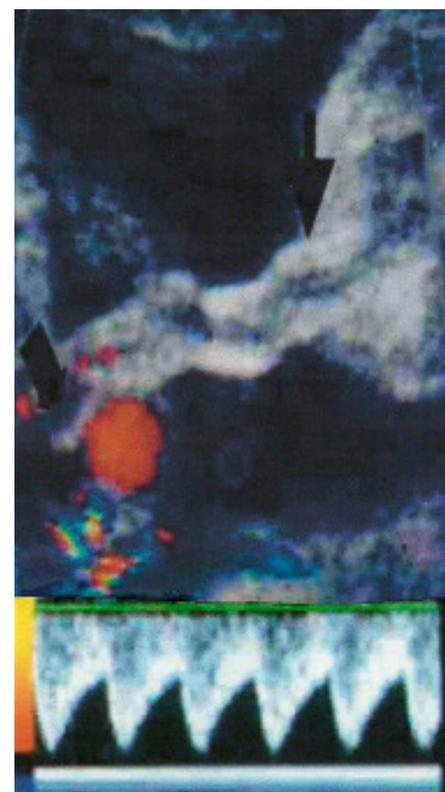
b: Doppler showing reverse blood flow from pump twin to perfused twin
